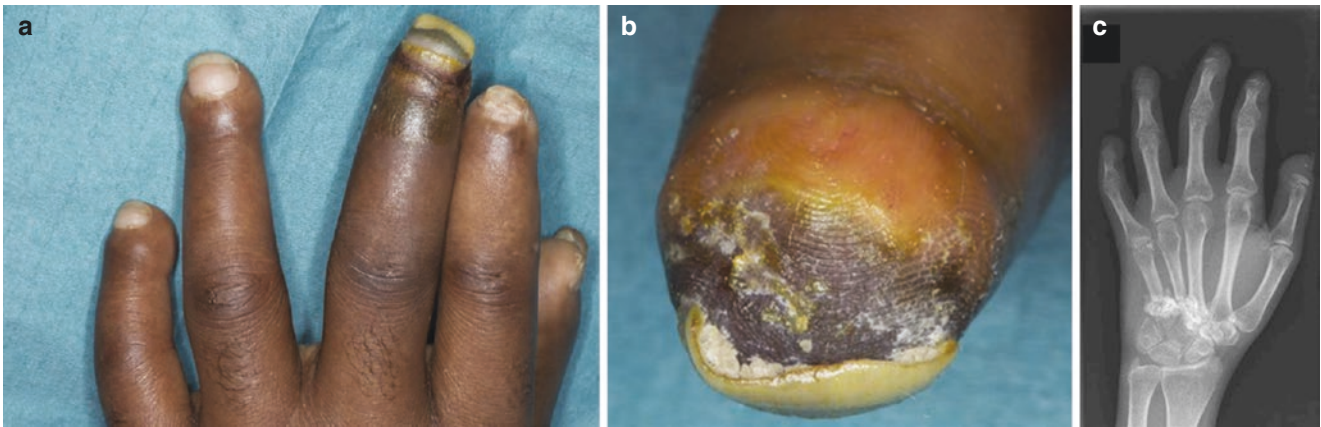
Infected digital tip ulcer. (a) Ulcer at the tip of left middle finger with increased swelling and discolouration extending to the proximal interphalangeal joint. Inset (b) shows the fingertip ulcer with indistinct ulcer border. (c) Radiograph showed acro-osteolysis affecting all distal phalanges of the left five digits with exuberant calcinosis over the carpal bones with no clear loss of soft tissue over the middle finger tip
